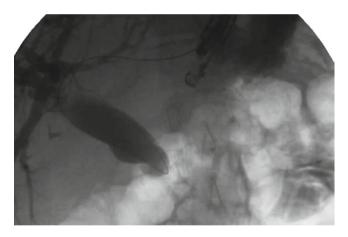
A guidewire is advanced through the endoscopic ultrasound needle and into the biliary tree.
